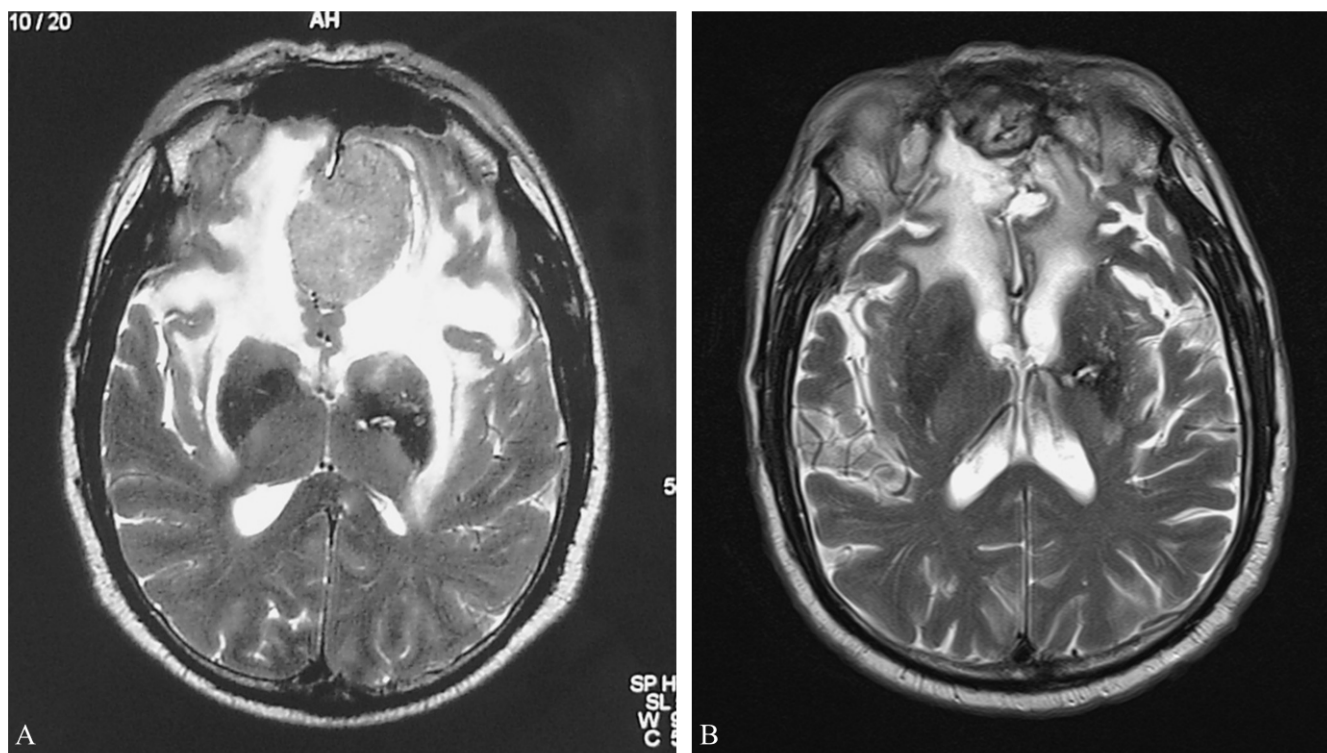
A) Axial MR T2-weighted images showing massive edema in the frontal white matter surrounding an OGM, extending posteriorly to the insulas and external capsules; B) reduction of edema after surgery, limited to fronto-orbital areas, with expansion of ventricles.
